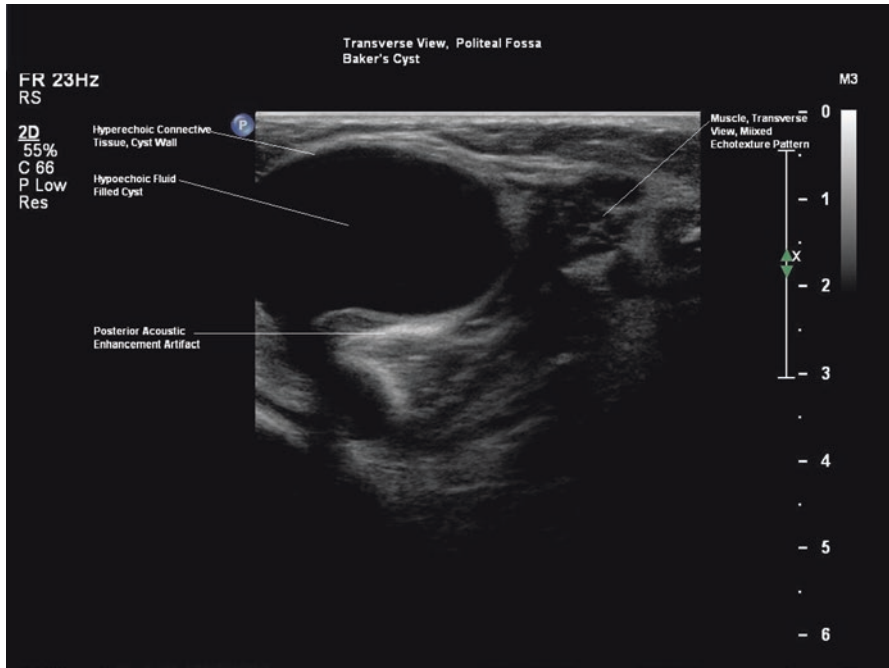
Transverse ultrasound image popliteal fossa, Baker's cyst with posterior acoustic enhancement
